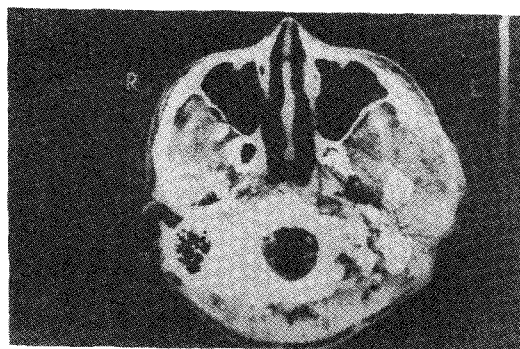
CT image for tumor region of parotid cancer.
